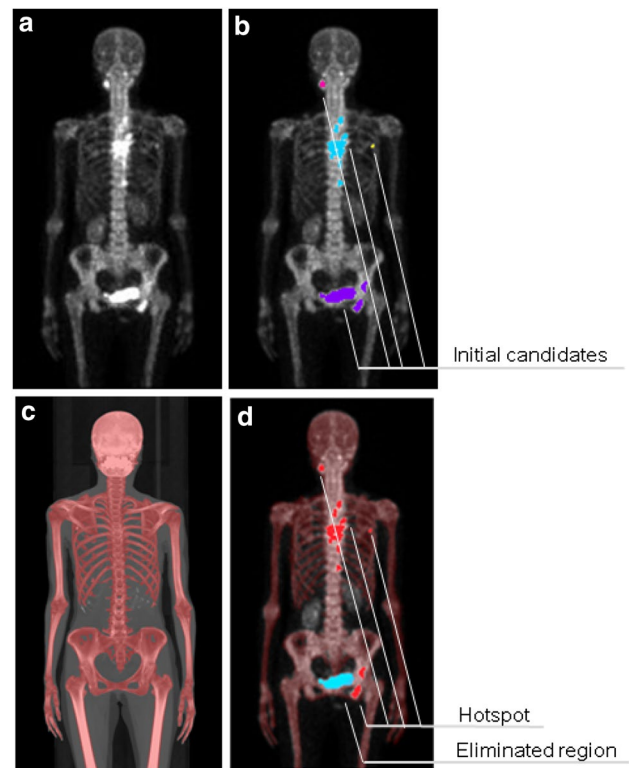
Initial detection of increased uptake regions on SPECT images and exclusion of physiological uptake using CT images. a Original images, b initial candidates for increased uptake regions, c bone regions (red), and d results of masking
